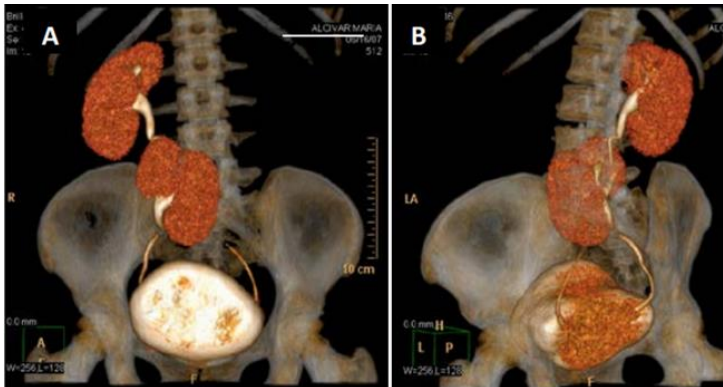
CT KUB with Right sided located ectopic left Kidney.
